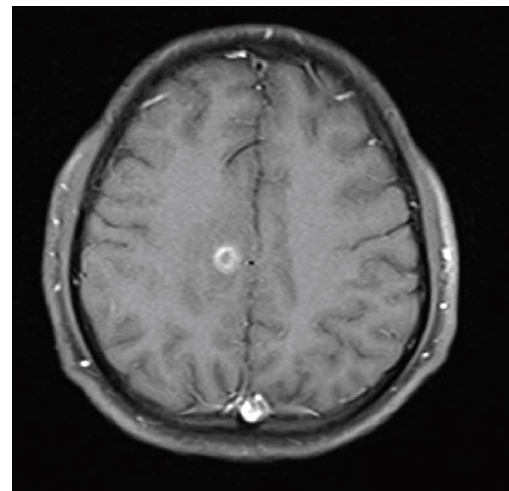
A well-defined thick-walled ring enhancing lesions in MRI
